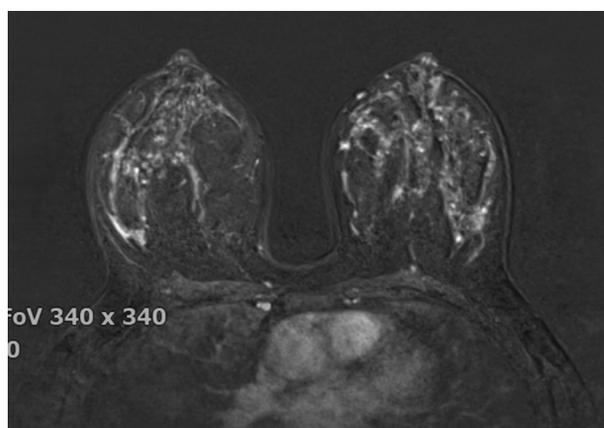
Axial T1-weighted fat-suppressed contrast-enhanced breast MR images showing minimal background parenchymal enhancement
